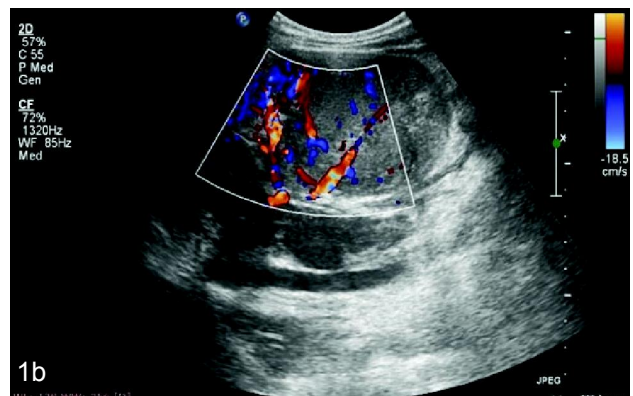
Ultrasonographical appearance of the mass in sagittal section (a) 2D grayscale mode showing the mass between spleen and left kidney and (b) Colour doppler showing increased vascularity of the mass.
